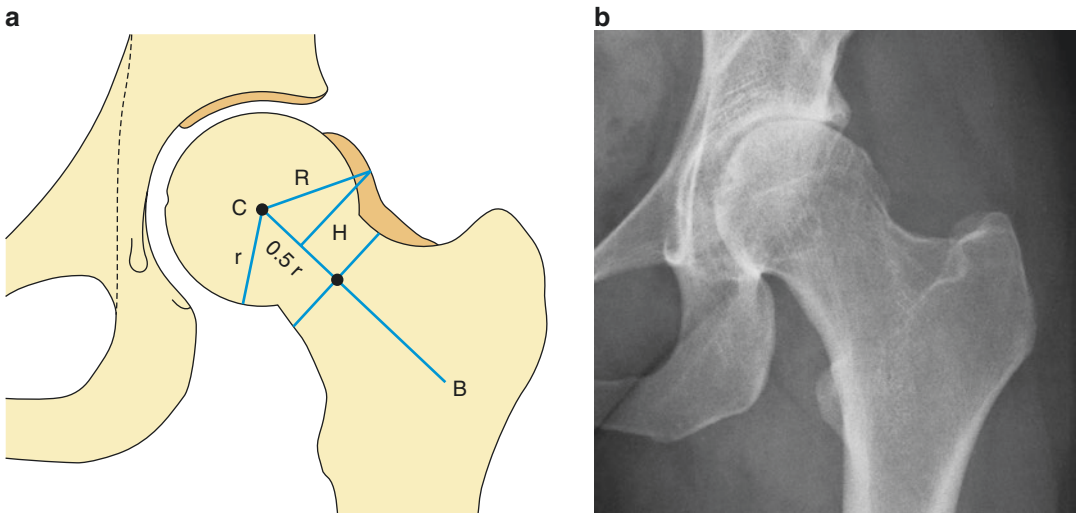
Cam effect—triangular index measurement technique (a) with radiographic depiction of the bony bump on the AP view (b)
